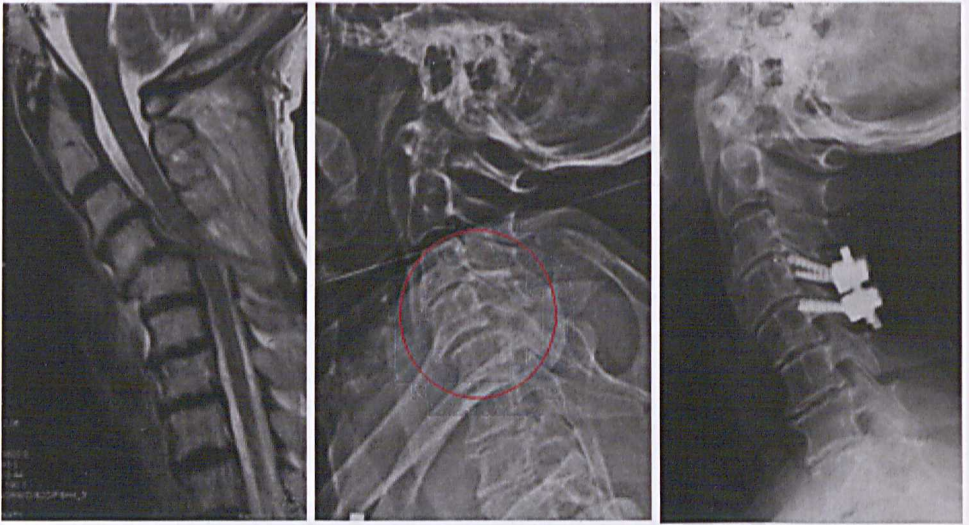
Elderly lady with traumatic C4/5 cervical subluxation with no disc prolapse, it was reduced and fixed posteriorly in theater under neurophysiological monitoring (MRI, cervical radiograph lateral: pre operative and post operative)
